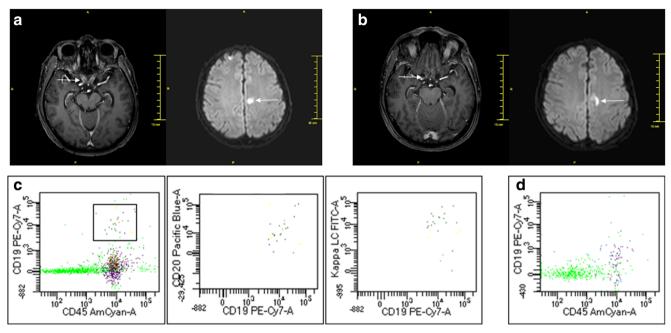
a Patient 1 pre-treatment axial contrast-enhanced T1-weighted MRI image about the infiltration of the optic nerve and diffusion weighted MRI image of the tumor in the parietal lobe. b post treatment MRI images. c Patient 2 Mature (CD19, CD20, CD45 positive), Kappa LC
